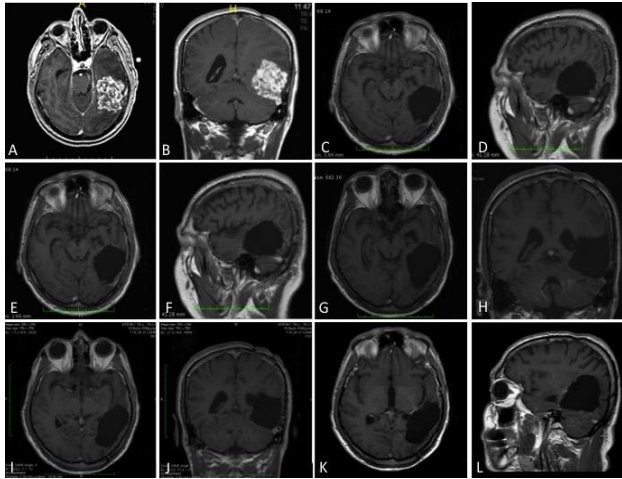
A, B: Pre-operative third MRI showing enlarged contrast enhancing mass. C-L: Post-operative follow-up MRIs showing no residue or recurrence.
